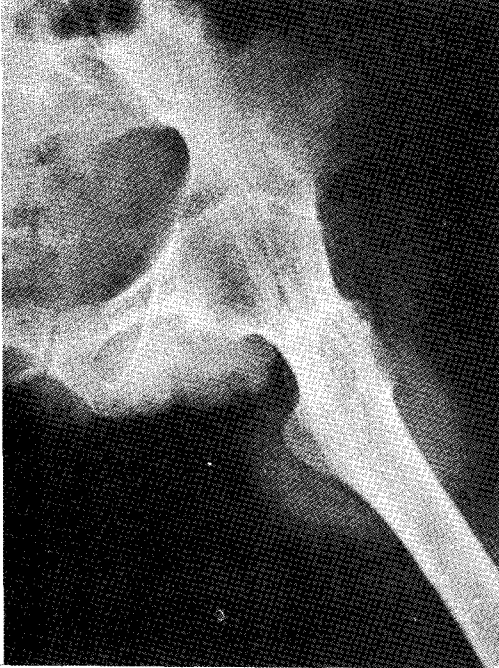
Pre-operation x-ray shows a marked ankylosed hip.
